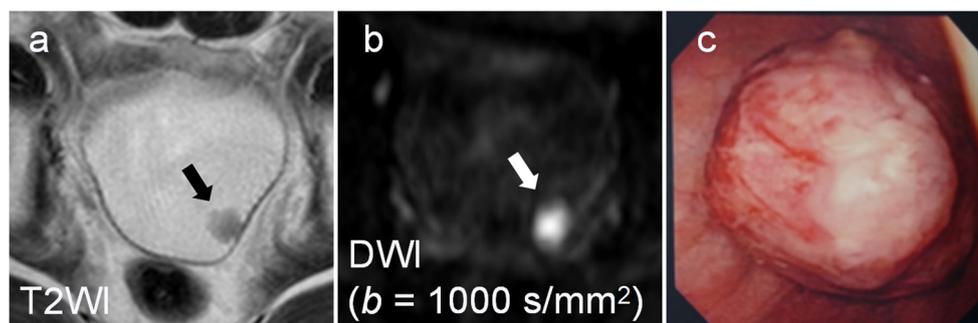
Magnetic resonance (MR) images and cystoscopic findings from a 75-year-old man with grade 3, pT1 bladder cancer. The patient experienced recurrence of the pT2 bladder cancer 16 months after transurethral resection of the bladder tumor. a Transverse T2-weighted MR image shows a small tumor on the left bladder wall (black arrow). b
